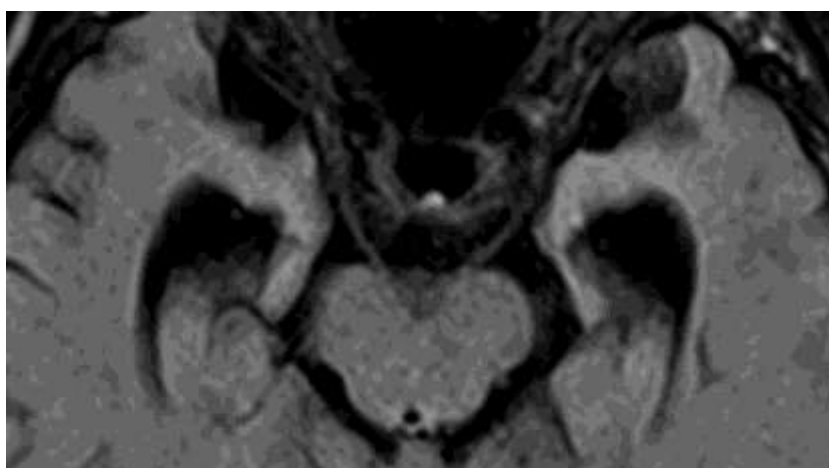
Bilateral mesial temporal sclerosis is seen in axial FLAIR image.
